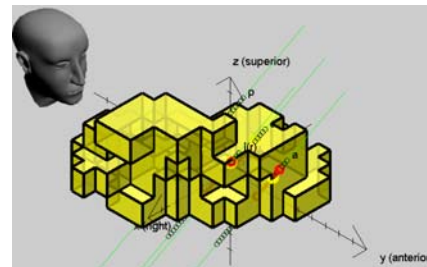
Result of automatically matched MRI and MER data with positions of electrodes intersecting STN model
